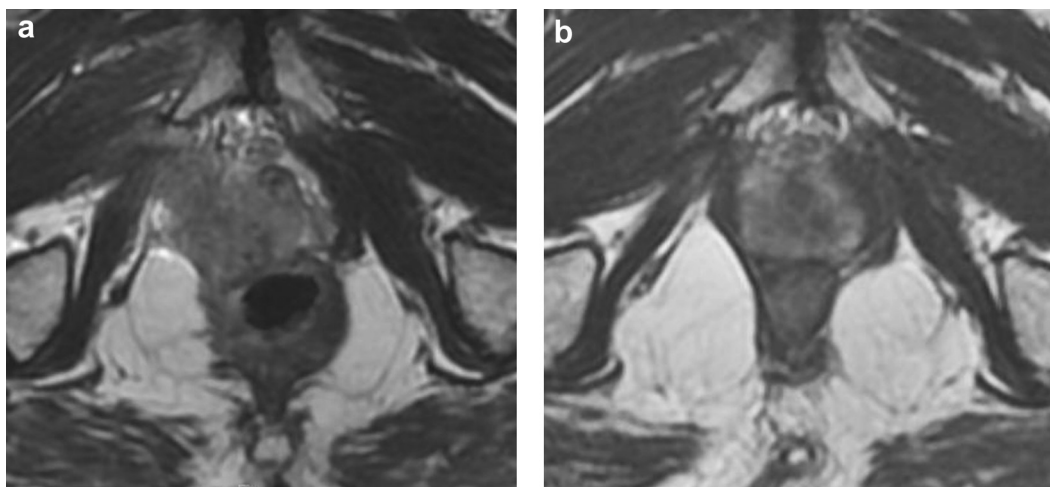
T2 weighted axial MRI images at the level of the prostate apex demonstrating local effect of ADT. (a) Image taken prior to ADT. (b) Image taken post ADT.
